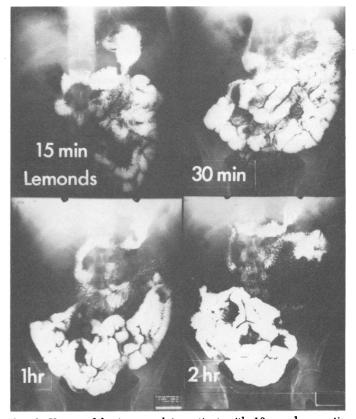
X-rays of barium meal in patient with 10 cm. long antiperistaltic jejunal segment which acts as substitute pylorus to delay gastric emptying. Segment functions effectively 10 years after remedial operation.
